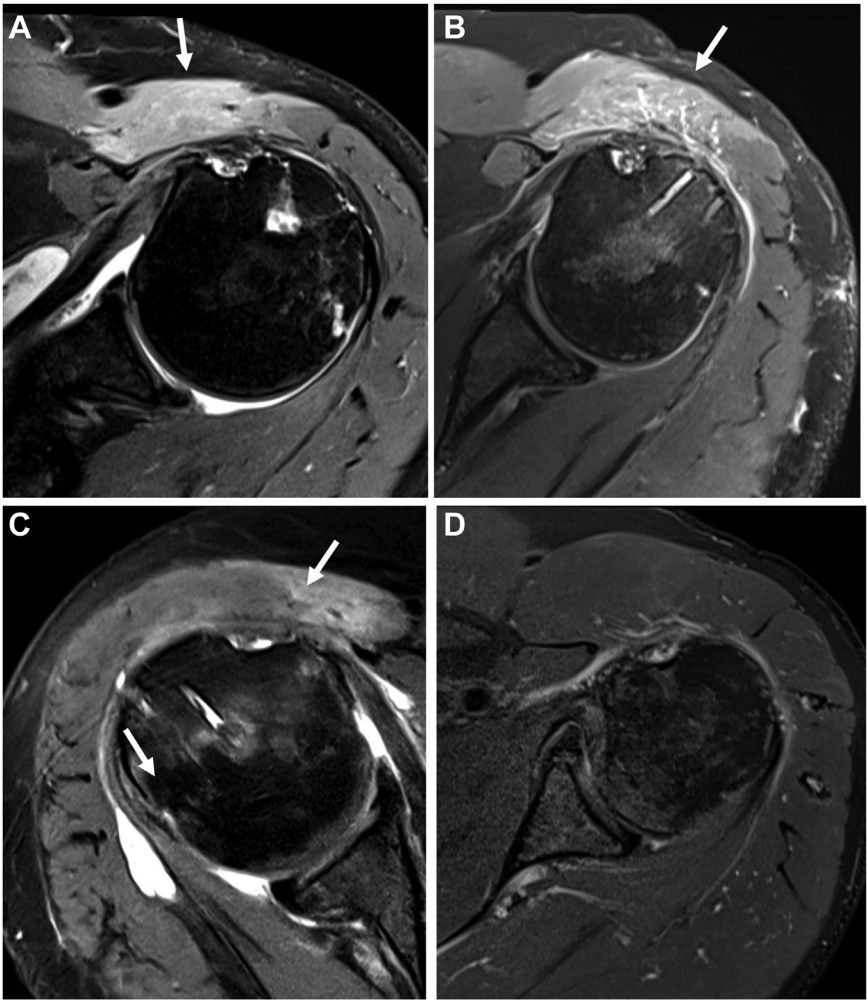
Deltoid signal in postoperative magnetic resonance imaging. (A–C) Proton density fat saturated MRI axial sequences of the shoulder demonstrating increased signal in the anterior deltoid musculature (white arrows). (D) Normal deltoid musculature for comparison. MRI, magnetic resonance imaging.
